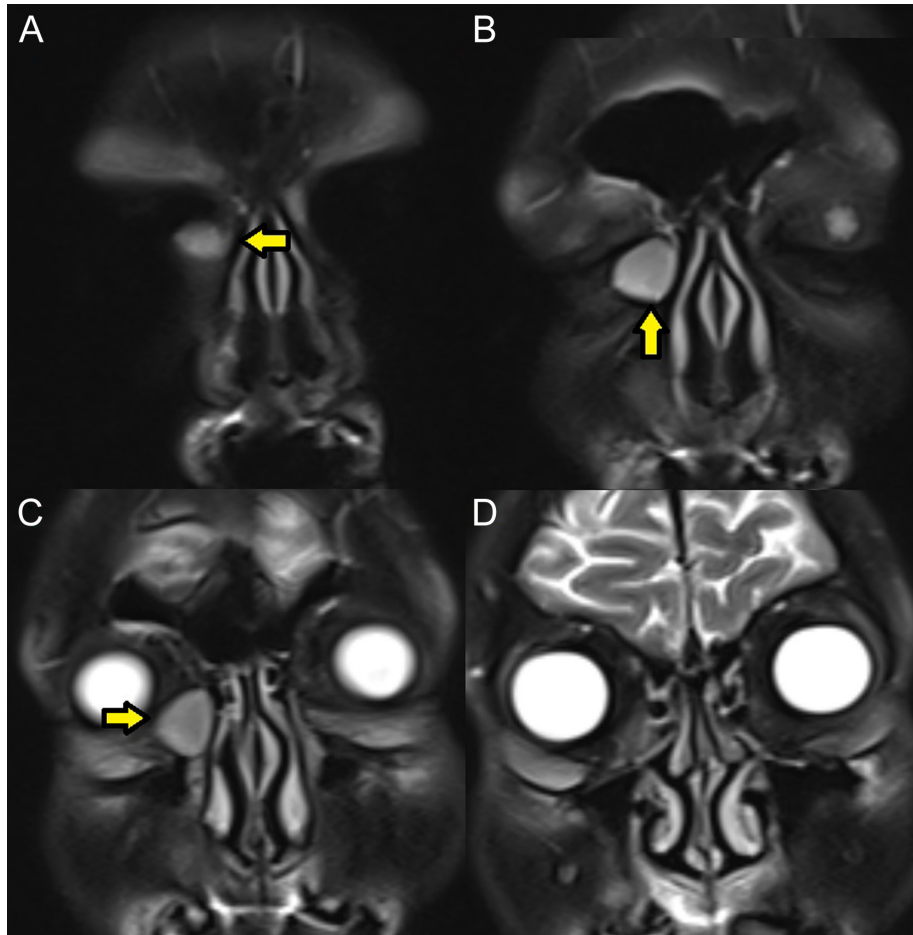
T2-weighted coronal plane consecutive MR images indicate the hyperintense lesion consistent with dacryocystocele (yellow arrows).
